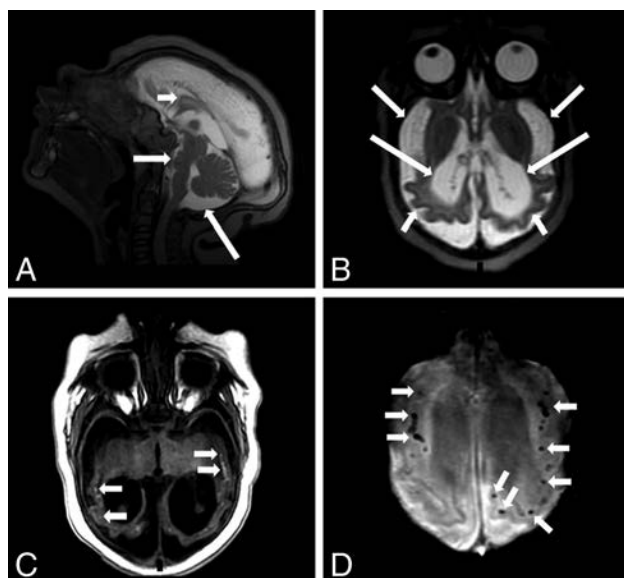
MR imaging of a 4-month-old boy with microcephaly with confirmed congenital Zika syndrome. Sagittal T2-weighted image (A) shows a hypogenetic corpus callosum (*short white arrow*), pons hypoplasia (*medium white arrow*), and an enlarged cisterna magna (*long white arrow*). An axial T2-weighted image (B) shows a diffuse simplified gyral pattern (note the thin cortex) (*short white arrows*), an enlarged extra-axial CSF space (*medium white arrows*), and severe ventriculomegaly (*long white arrows*). An axial T1-weighted image (C) shows hyperintense punctate foci, representing calcifications, at the cortico-subcortical white matter junction (*small white arrows*). Axial SWI (D) shows several punctate foci at the cortico-subcortical white matter junction (*short white arrows*).
